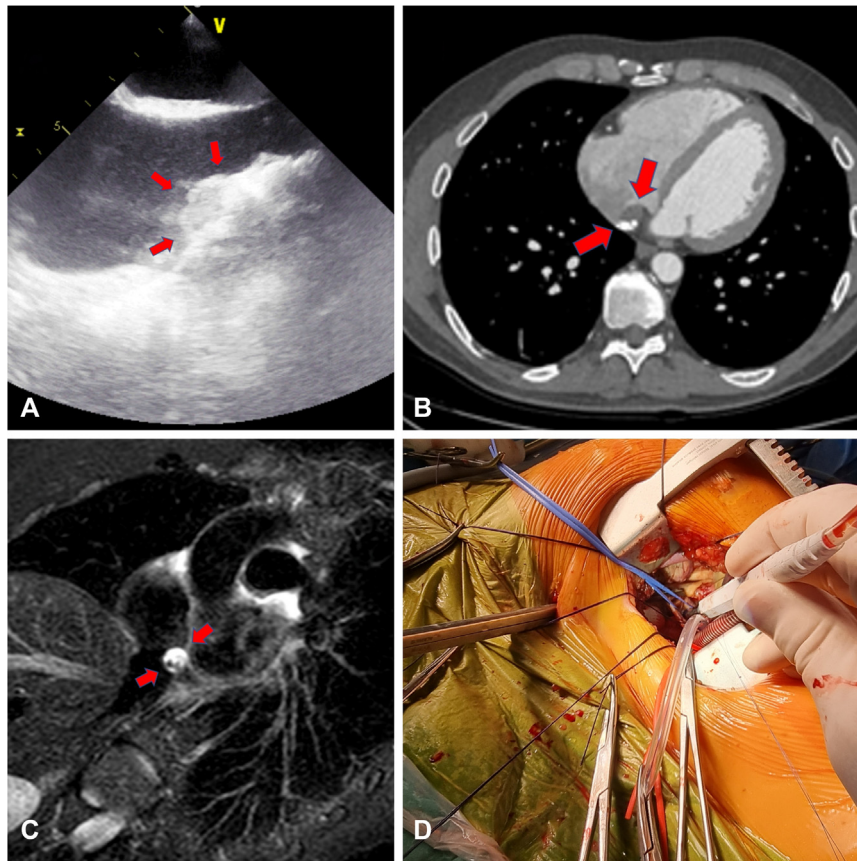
A, Echocardiographic image of nonspecific thickening of the interatrial septum. B, Cystic lesion with calcium densities inside adhered to the interatrial septum by computed tomography. C, Nuclear magnetic resonance image in T2 STIR (short inversion time inversion recovery) sequence. D, Minimally invasive approach by right anterolateral mini-thoracotomy.
